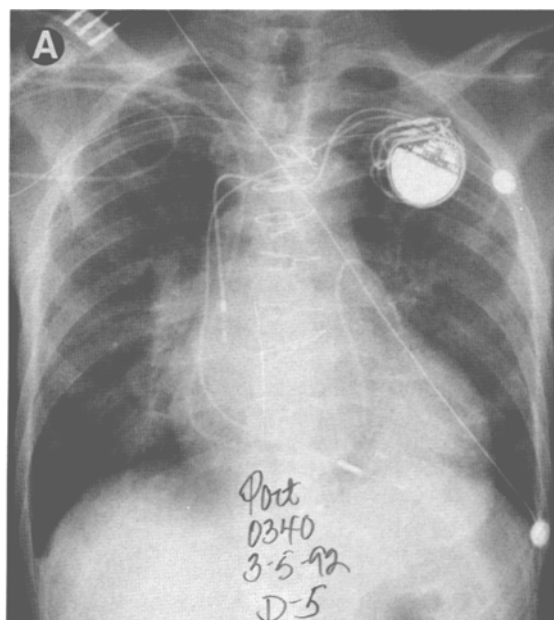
(A) Original portable chest radiograph with an underexposure level of 50% of the proper exposure level. (B) Digitized processed chest radiograph that is diagnostically superior, especially for mediastinal and upper-abdominal detail.
